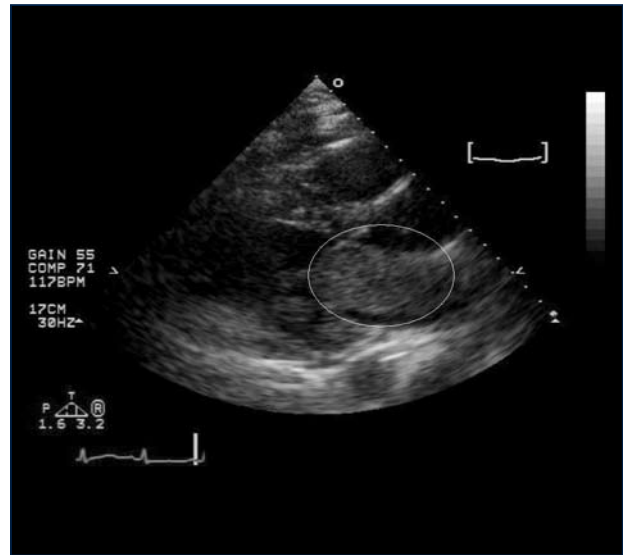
Transthoracic echocardiogram in the left parasternal long axis view showing an approximately 11 cm² left atrial mass (outlined) attached to the distal atrial septum consistent with myxoma.
